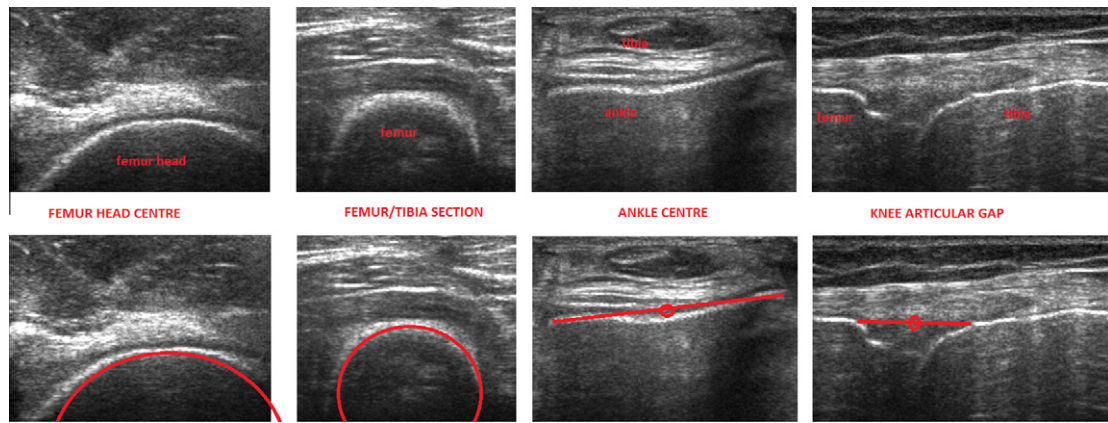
The recorded ultrasound scans of the lower limb.
